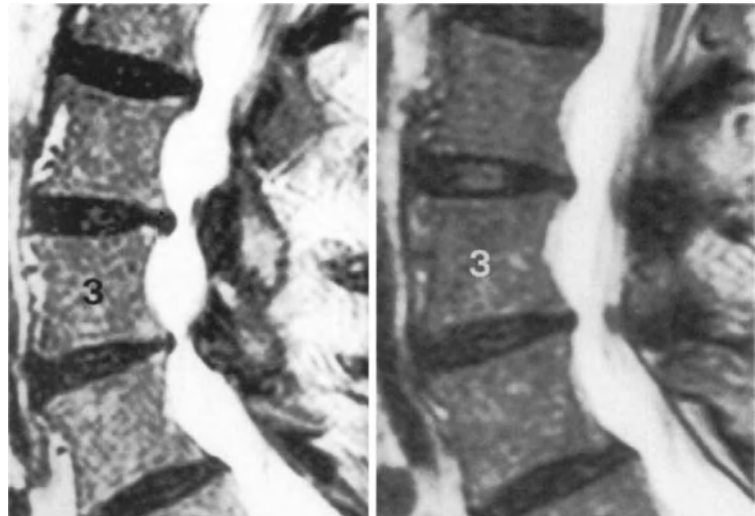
Constitutional spinal canal stenosis and disc bulging at multiple levels. Spin-echo T2-weighted sagittal MR images showing constitutional spinal canal stenosis at L2-L3 and L3-L4 levels; disc bulging is mild at L3-L4 level and more marked at L2-L3 level. Mildolisthesis of L4 is also present.
